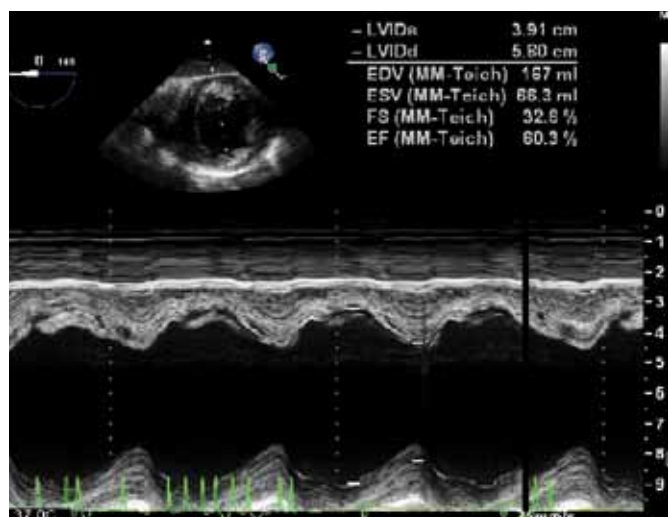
Assessment of left ventricular function (Transgastric mid short axis view). Doppler has been applied across the left ventricle. Movement of the inferior and anterior walls are plotted against time (M mode). EF, ejection fraction; FS, fractional shortening; LVIDs, left ventricular internal diameter in systole; LVIDd, left ventricular internal diameter in diastole.
